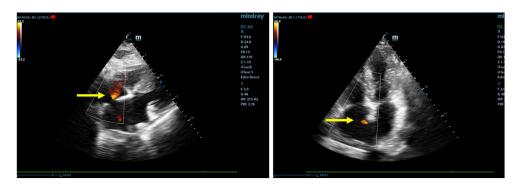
b.10. Patent foramen ovale (arrow) in presented case (color Doppler; left: subxiphoid view, right: apical 4-chambers view)
